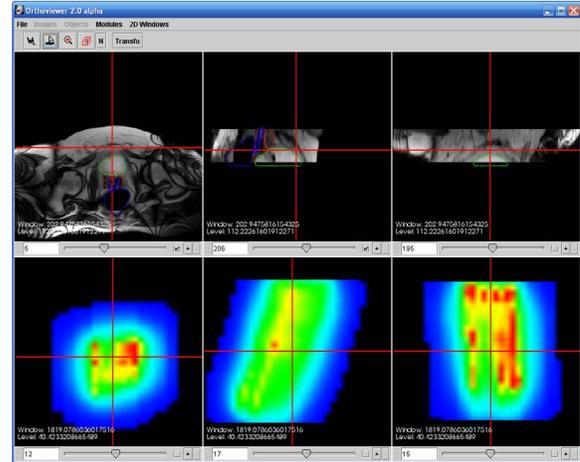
The MR images and the optimized dose map.
